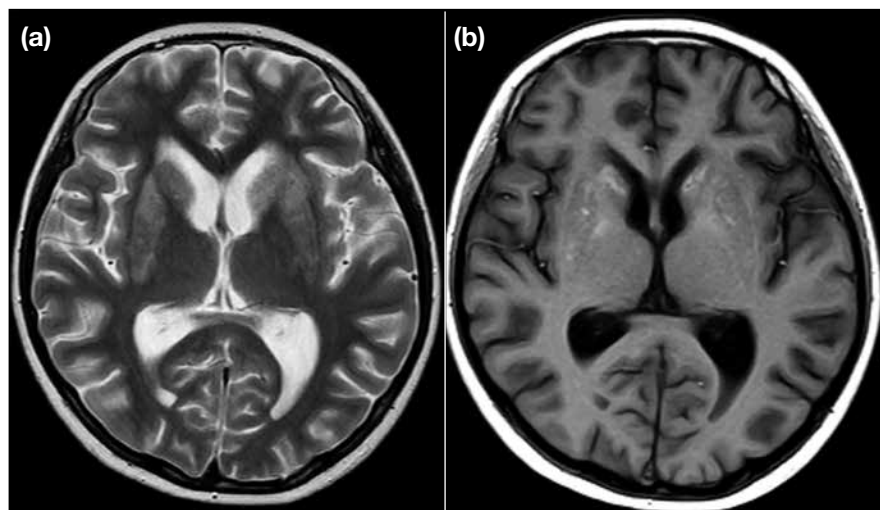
Follow-up magnetic resonance imaging of the brain at 3 weeks from baseline. (a) Axial T2-weighted image demonstrates markedly reduced T2 signal abnormality with atrophic change of the caudate and lentiform nuclei. Note that there is associated ex-vacuo dilatation of bilateral frontal horns relative to the baseline image. (b) Axial T1-weighted image shows new T1 hyperintense signals within caudate and lentiform nuclei without susceptibility artefacts, consistent with coagulative necrosis.
